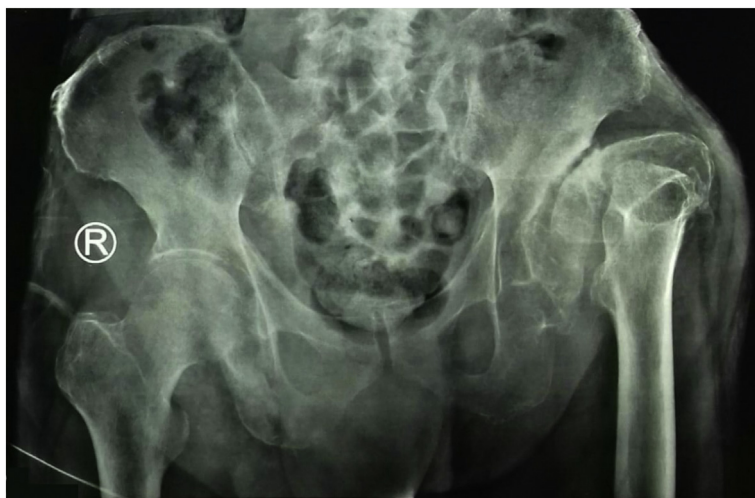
Radiographic image of hip initial condition.
